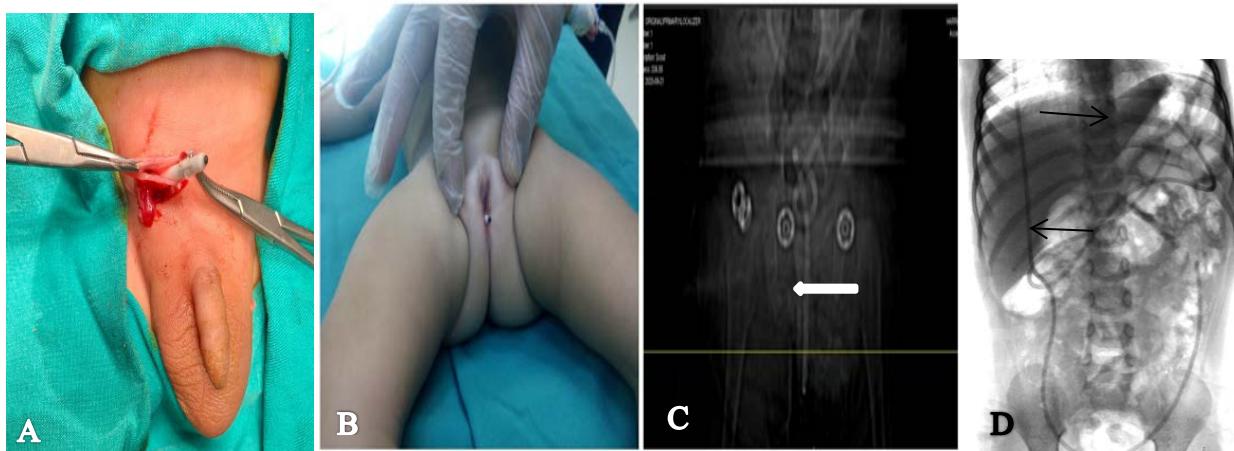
A-spontaneous extrusion of the distal end of the VPS through the inguinal canal, B- uretra, C- X-ray shows that the distal end (white arrow) has passed through the abdominal wall into the bladder, formed a knot, and protruded outward through the urethra, D- complete detachment of the distal end of the VPS within the peritoneal cavity (black arrow).
